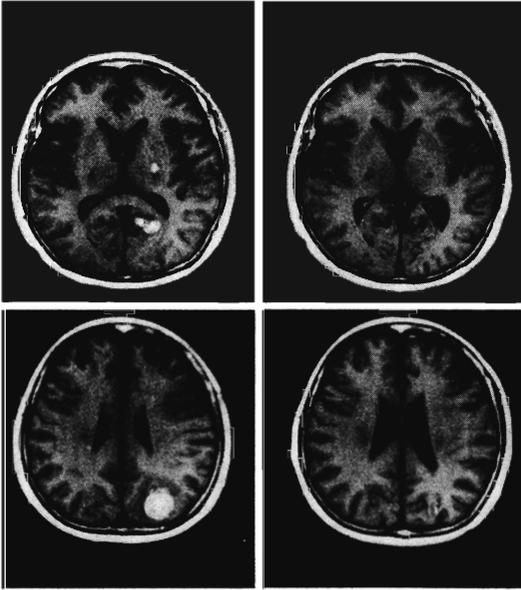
(Top left) Contrast-enhanced CT scan before chemotherapy reveals a left occipital tumor with surrounding edema. (Top right) After 2 courses of CEF; (Bottom left) after 4 courses of CEF; (Bottom right) CT scan shows that after 6 courses of CEF occipital tumor had almost disappeared.
